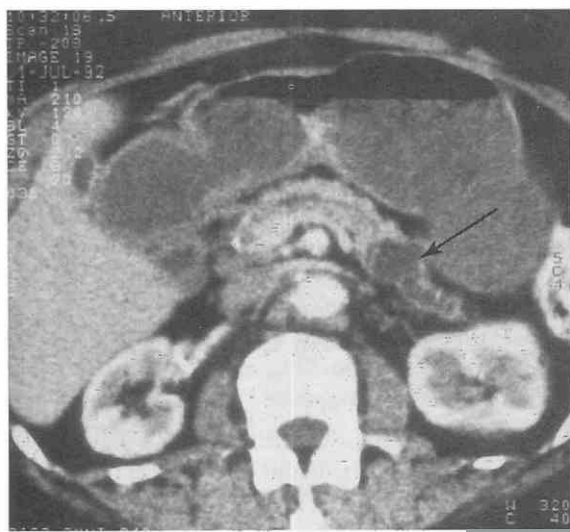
CT scan shows mild dilatation of the central portion of the duct with saccular dilatation distally (arrow), resulting in a retention cyst.
